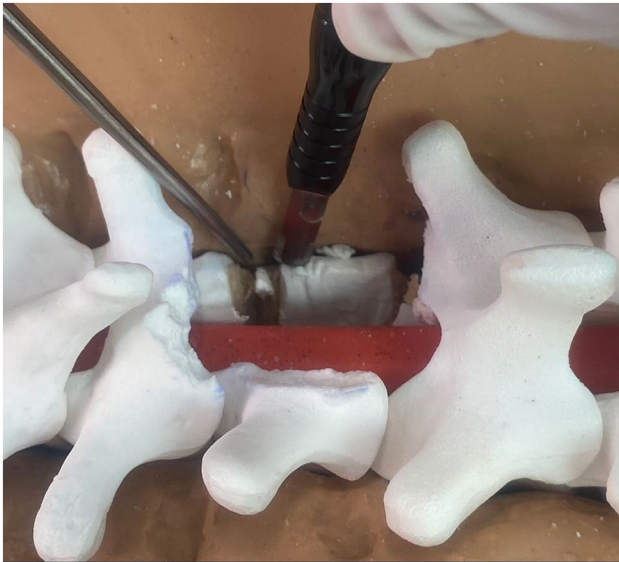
The fine tip of the ultrasonic bone scalpel allows the lateral vertebral body to be carefully tailored to the desired width rather than resected en toto as demonstrated on this molded plastic spine model
